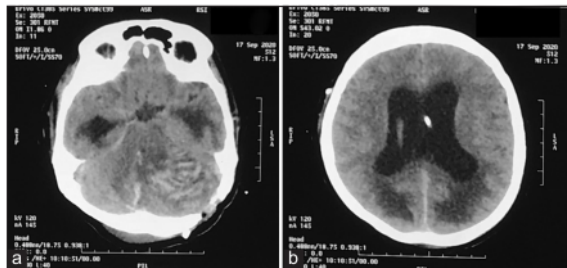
CT imaging 2 days postoperative shows increase of cerebellar edema and hemorrhagic on cerebellum (a) and hydrocephalus with extracranial drainage device placement (b).
